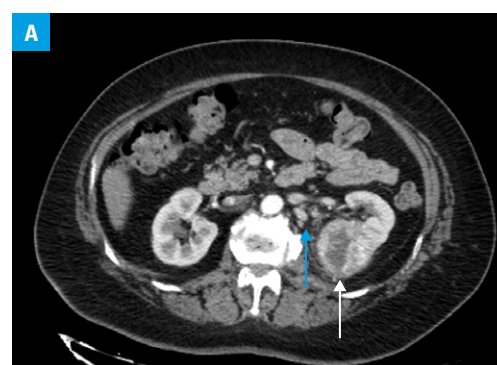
A – an axial computed tomography (CT) scan with intravenous contrast administration revealing hypervascular renal tumor (white arrow) and pathologic retroperitoneal lymph nodes (blue arrow)
